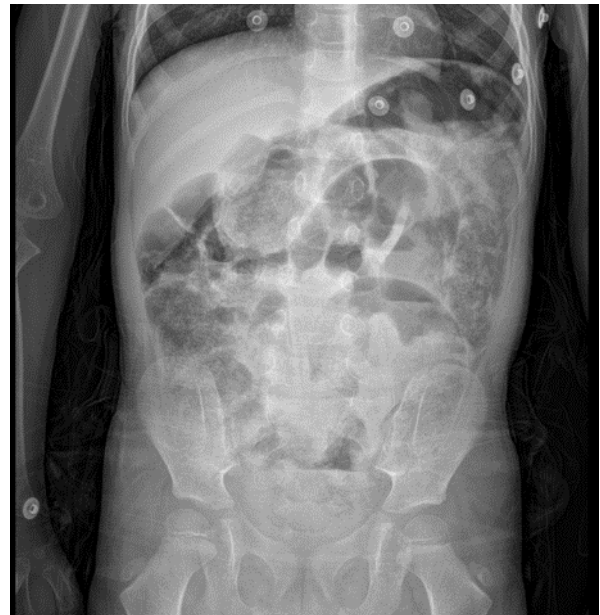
Standing Abdominal X-ray taken following the administration of the enema
